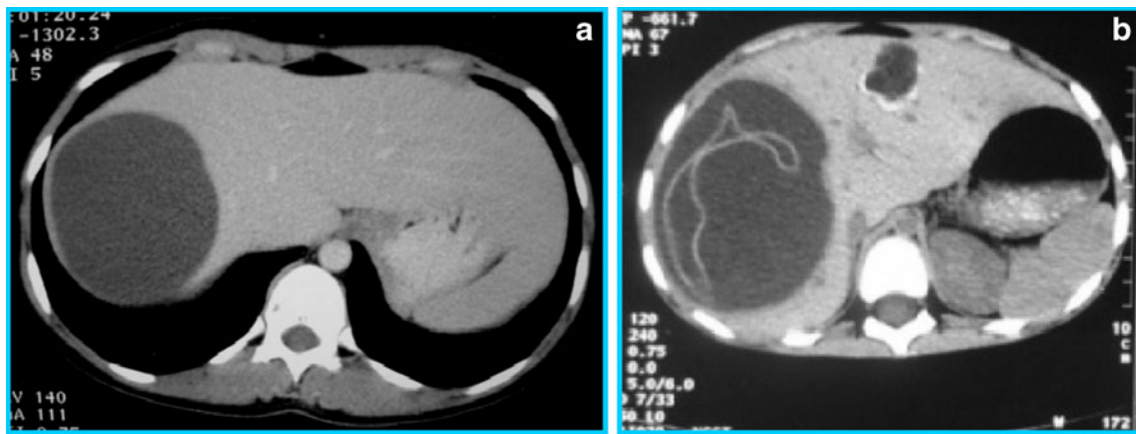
Contrast-enhanced CT scan showing hydatid cyst of liver. a Type I b Type II
